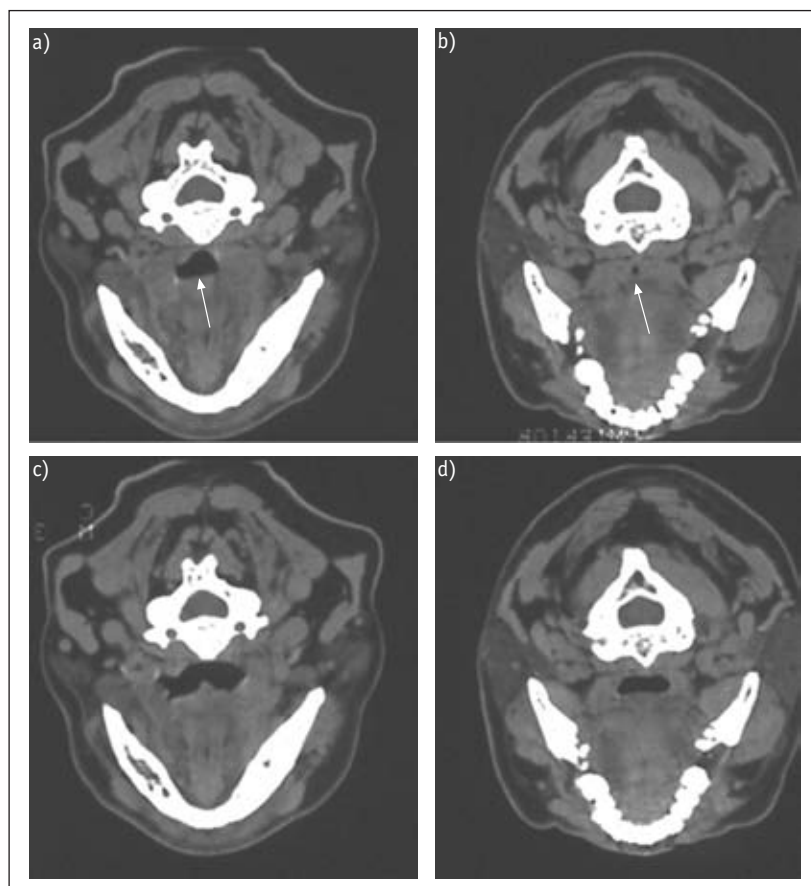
Axial CT scans of the upper airway obtained during sleep from a patient with OSAHS. a) and b) Two head sections of the untreated patient. c) and d) The same two sections during application of CPAP. The yellow arrows indicate the upper airway lumen.
